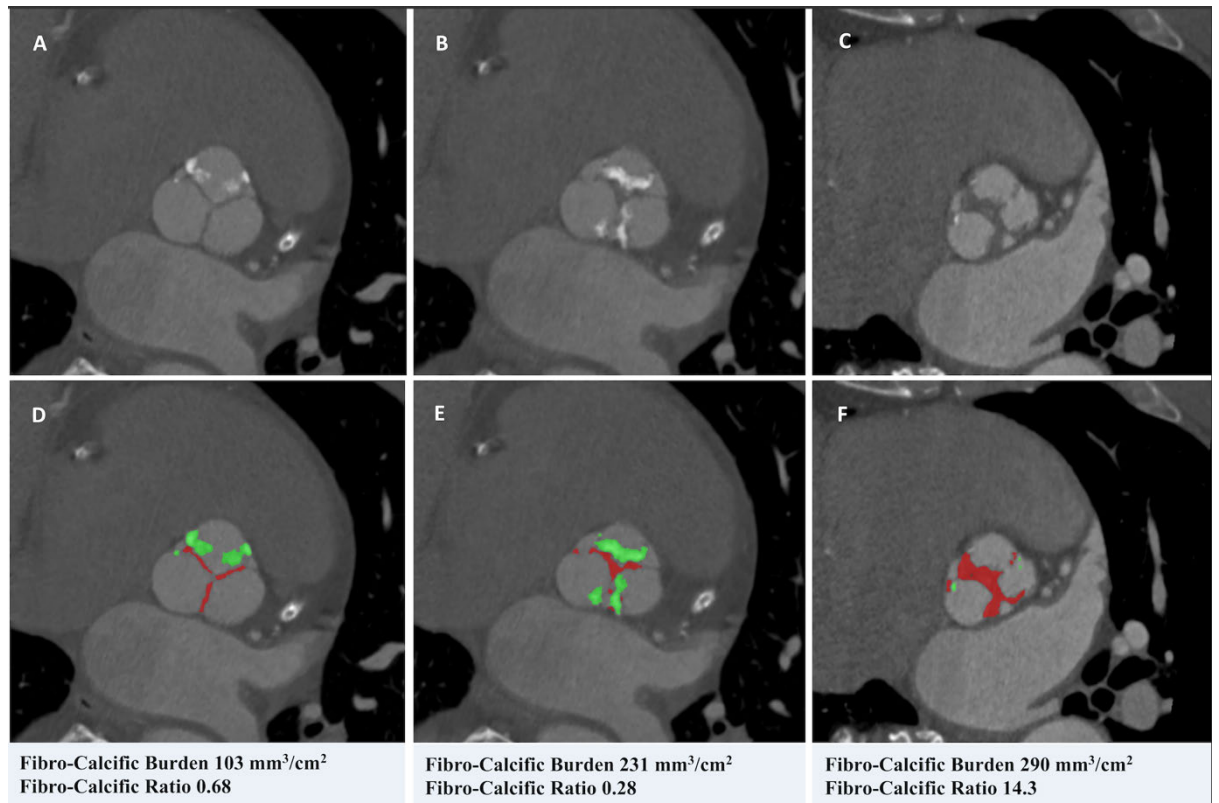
Contrast-enhanced CT images in the *en face* plane of the aortic valve (A-C) with calcium highlighted in green and non-calcific fibrotic leaflet thickening highlighted in red (D-F). The total fibro-calcific burden (mm^3/cm^2) and the fibro-calcific ratio are presented beneath.
